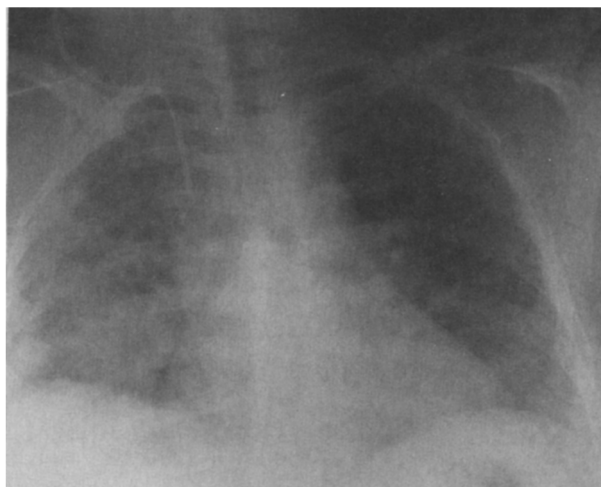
Chest radiograph showing position of right internal jugular catheter.
